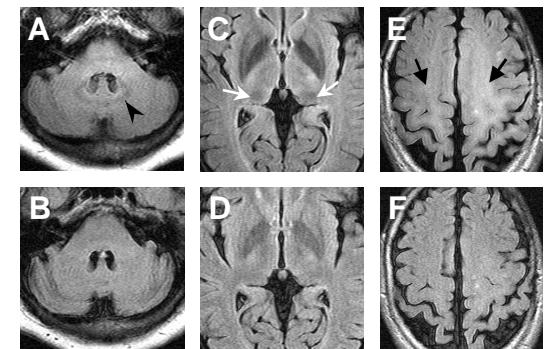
Fast FLAIR images at 3.0 T (A, C, E) show hypointensities in the dentate nucleus of cerebellum (A, arrowhead) and pulvinar thalami (C, white arrows) and hyperintensities at the both centrum semiovale (E, black arrows). These findings are absent on the corresponding 1.5 T images (B, D, F).
